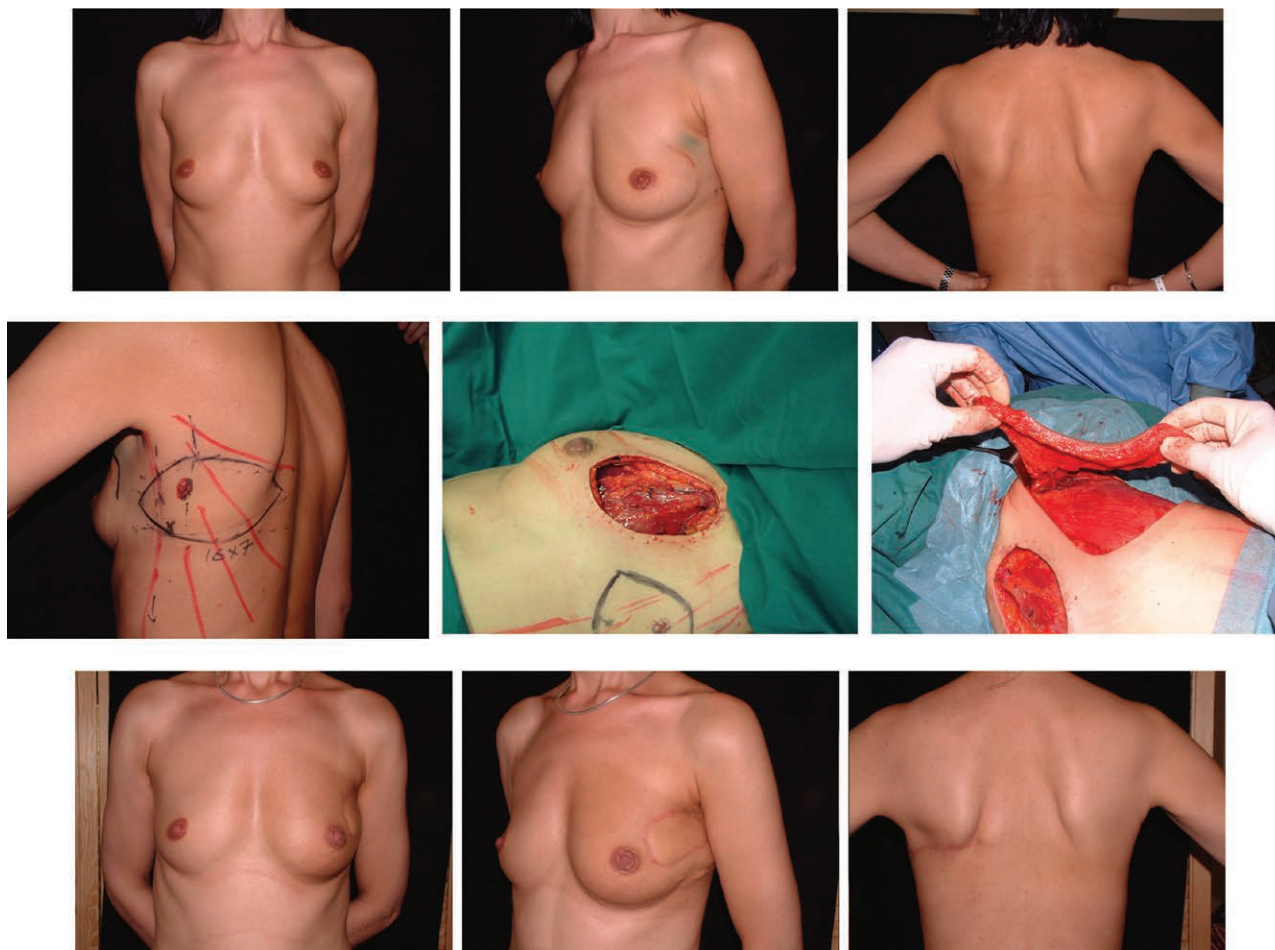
(Above) This is a 44-year-old patient who presented with a T2 tumor in the left breast. An immediate breast reconstruction was planned because of the expected unaesthetic result after tumor resection in such small size breast. Her marking are demonstrated (middle) and perforators were mapped preoperatively by unidirectional Doppler. The defect involves skin and parenchyma in the upper-lateral quadrant (below) and was reconstructed immediately with a pedicled thoracodorsal artery perforator flap harvested on 1 perforator. Her result is shown 1 year postoperatively. (Used with permission from Losken A, Hamdi M. Partial breast reconstruction: current perspective. *Plast Reconstr Surg.* 2009;124:722–736.)
